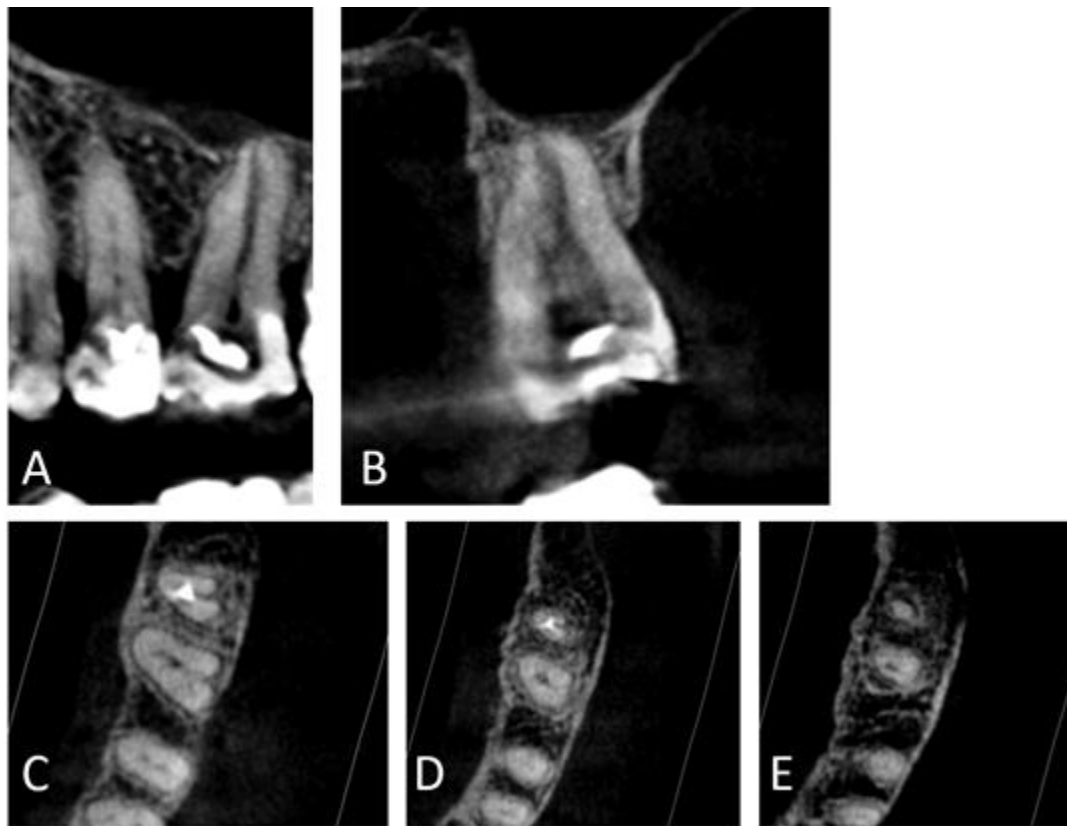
A – Cone-beam computed tomography images of left permanent maxillary first molar on transversal cross-section; B – sagittal cross-section; C – axial cross-sections on coronal; D – medial level; E – apical level.
